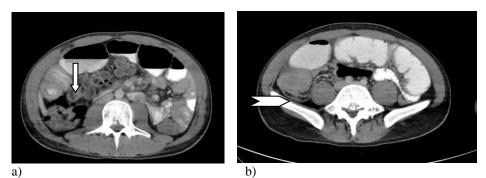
Diffüse Hodgkin Lymphoma in a 45-year-old man who presented with a history of abdominal pain, vomiting. A contrast-enhanced CT scan shows an ileocolic intussusception(arrow)(a) with a thickening of the terminal ileum(arrowhead)(b).
